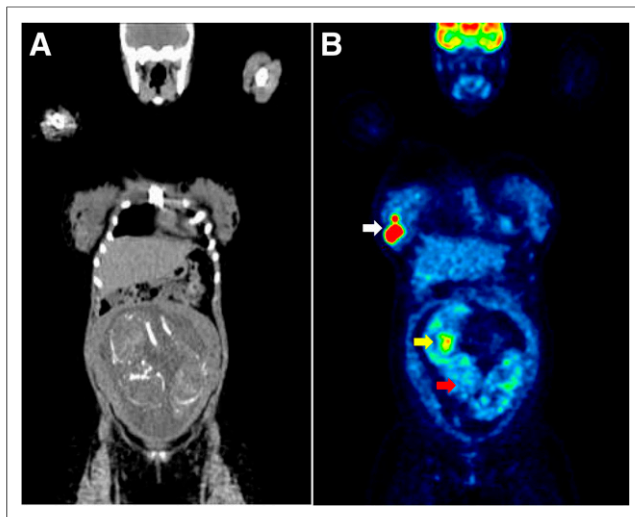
Coronal CT (A) and PET (B) image of 29-y-old woman diagnosed with diffuse large B-cell non-Hodgkin lymphoma while expecting twins (about 25 wk pregnant; fetuses 13 and 14 in Table 1). This image was acquired by the Department of Nuclear Medicine of the Henri Becquerel Center in Rouen, France. White arrow points to lymphoma mass in right breast that led to diagnosis. Similarly to all the other late-pregnancy fetuses, uptake in brain (red arrow of fetus on right) is significantly lower than uptake in brain of mother. Yellow arrow points to high ^{18}F -FDG uptake in myocardium of same fetus. Skeletons of the twins are visible on CT scan.
